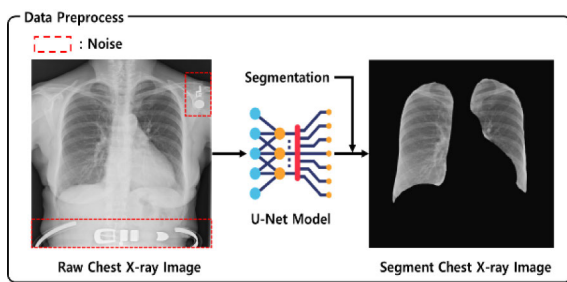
The preprocessing process of the chest X-ray data for the removal of unnecessary features.
